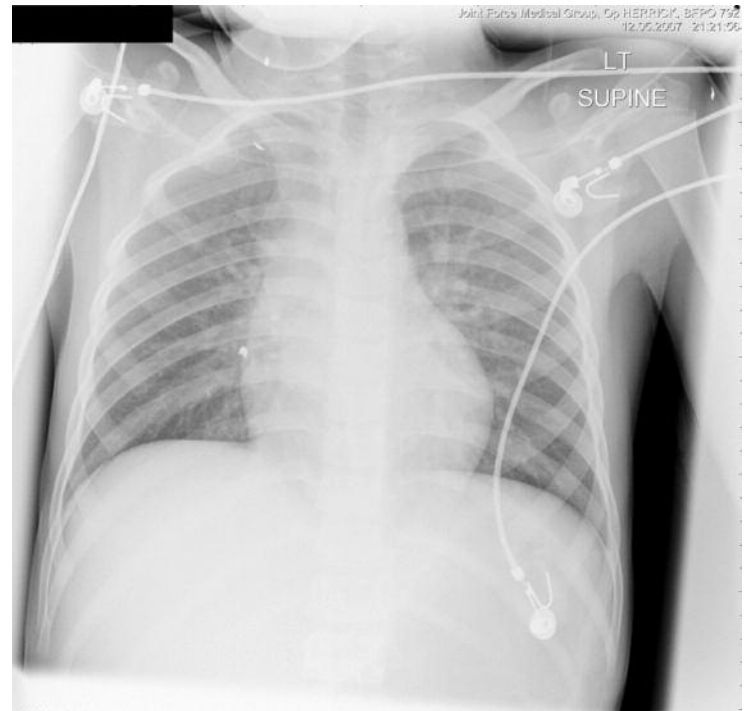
Chest x-ray showing fragments of land mine at right sternal edge and the globular heart of cardiac tamponade
